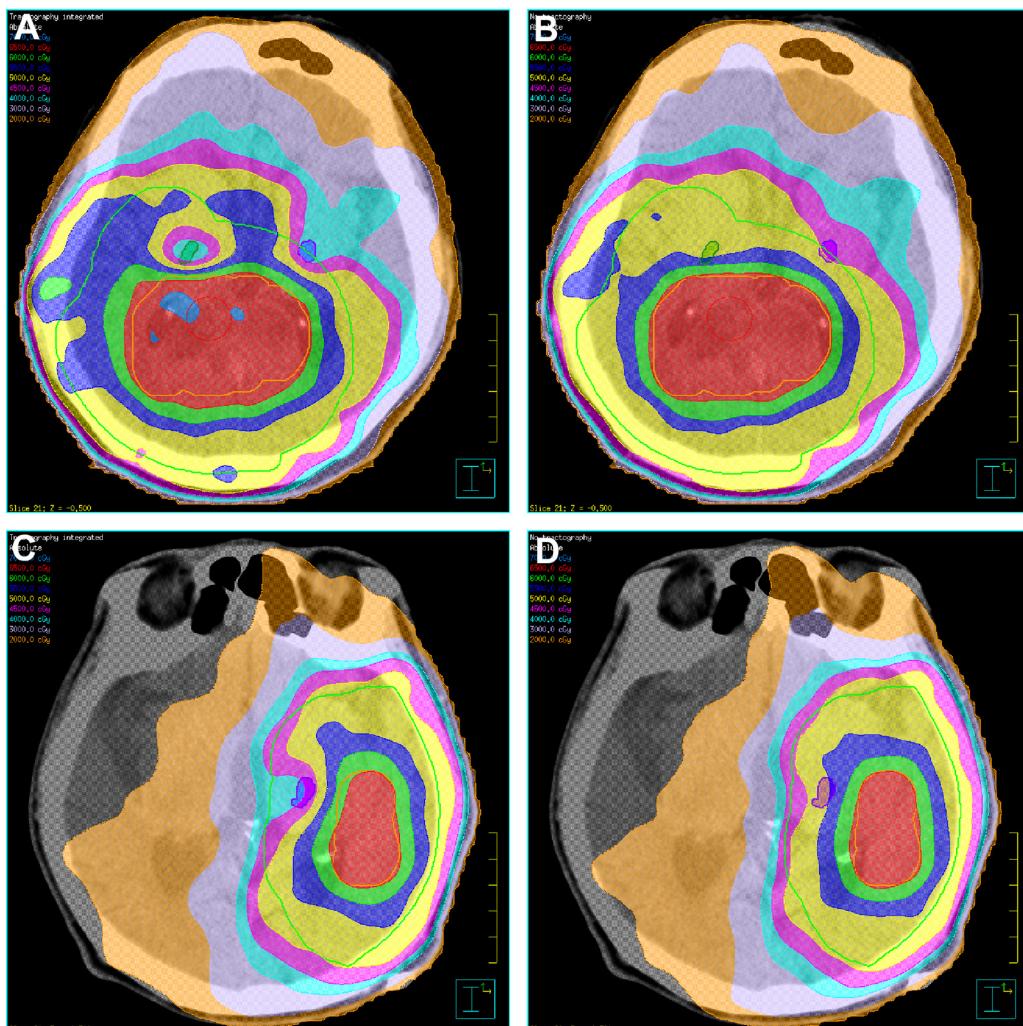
IMRT plans that protect the corticospinal tract. (A) An IMRT plan of case 1. Doses to bilateral corticospinal tracts were constrained under 50 Gy. (B) Another IMRT plan of case 1, made under the same sets of dose constraints but without that for the corticospinal tract using the same CT images as in A. (C) An IMRT plan of case 2 with the dose constraints for the corticospinal tracts. (D) Another IMRT plan of case 2 without the dose constraints for corticospinal tract using the same CT images as in C. PTV1 and PTV2 are portrayed in light green and orange, respectively; corticospinal tracts are portrayed in green (right) and purple (left).
